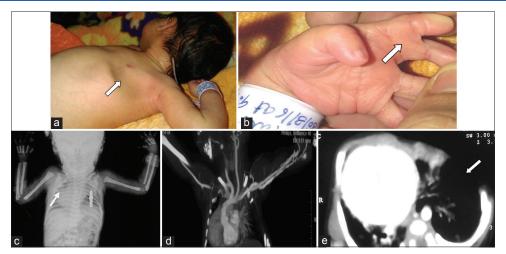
(a) Chest wall depression on left side, (b) syndactyly between index finger and middle finger in left hand, (c) X-ray chest showing hypoplastic 3rd and 4th ribs and dextrocardia, (d) computed tomography coronal section showing dextroposed heart, mesocardia, reduced right lung volume and absence of any subclavian artery narrowing, (e) computed tomography chest axial section showing absence of pectoralis major and minor on left side
